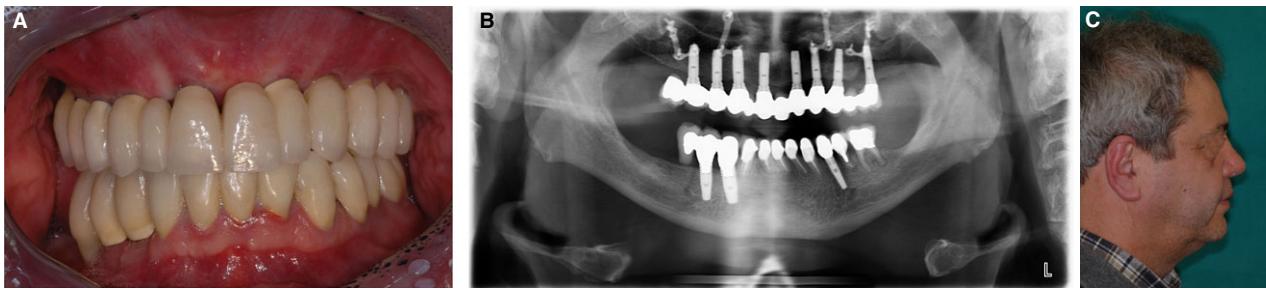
Clinical (A) and radiographic (B) appearance of the treated area, after the definitive prosthetic rehabilitation, demonstrates an excellent result from a prosthetic and functional point of view as well as a major improvement in the facial profile of the patient (C). (Bone augmentation and implant surgery, Dr Matteo Chiapasco.)
